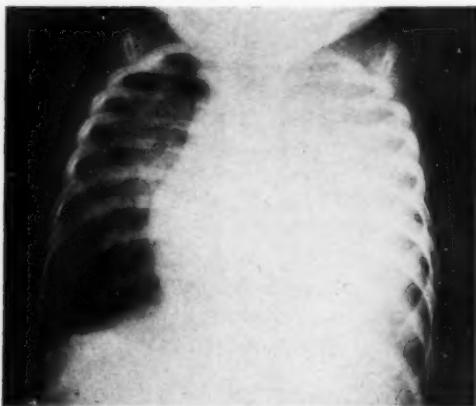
Case II. Roentgenogram at seven months of age, showing atelectasis and consolidation of the left lung with extensive infiltration in the right lung. Child expired on same day.
